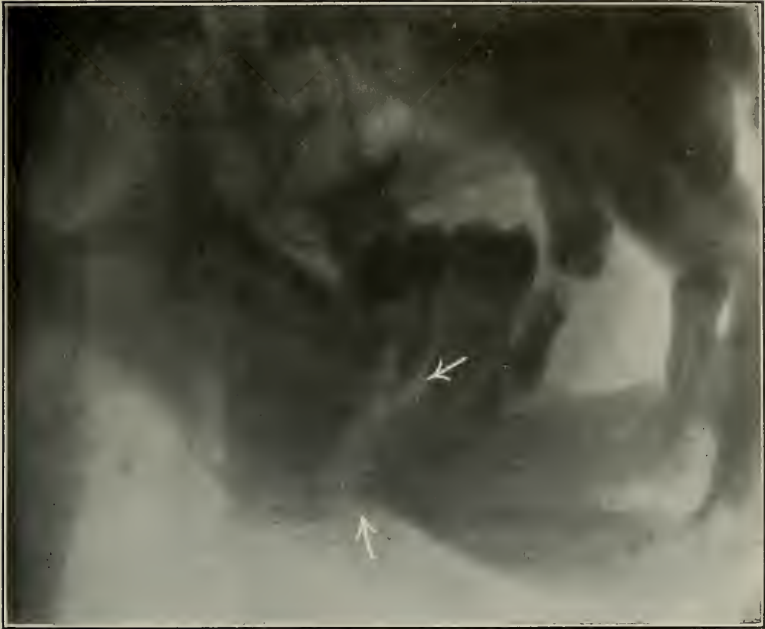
The arrows point to a fracture of the jaw in the region of the angle. (Radiograph by Cole and Raper.)
